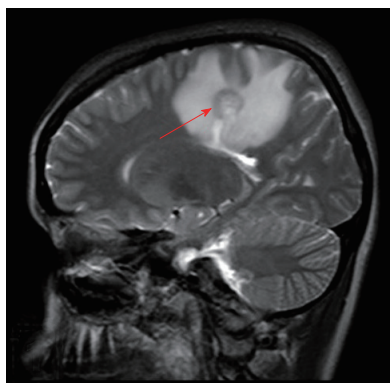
Sagittal T2-weighted magnetic resonance imaging showing a mass lesion with concentric rings located adjacent to the left lateral ventricle and posterior part of the corpus callosum with peripheral vasogenic edema.
